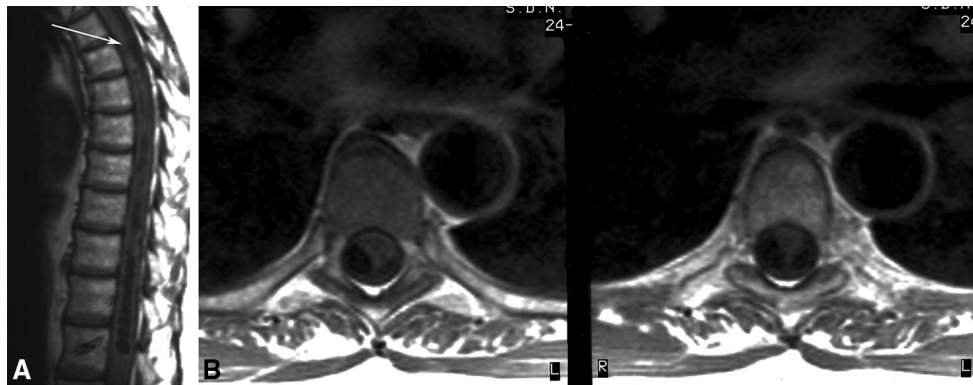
T1-weighted sagittal MR image showing thoracic syringomyelia with a scalpel sign adjacent to the upper pole of the syrinx (a). At the same level on axial images (b), arachnoiditis causes severe
